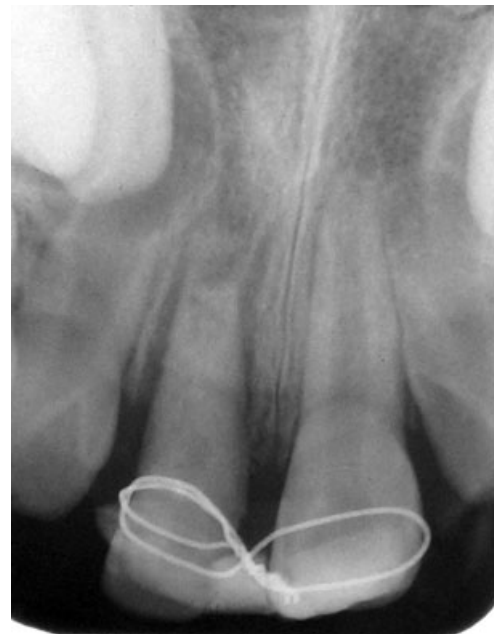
Radiographic view of the tooth after surgical extrusion.
